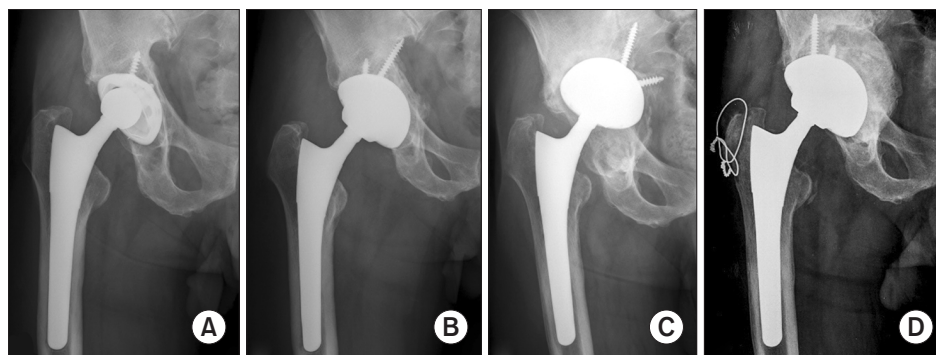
(A) A 71-year-old male patient underwent revision due to wear of polyethylene liner at 22 years after primary total hip arthroplasty. (B) The cup was changed with a larger one and the bearing surface was changed with Delta ceramic head and liner. (C) On the postoperative 2-year radiograph, the revised cup protruded into the acetabulum. (D) The acetabular defect was filled with allograft bone and the loose cup was changed with a larger one. The cup was stable at 11 years after the re-revision.
